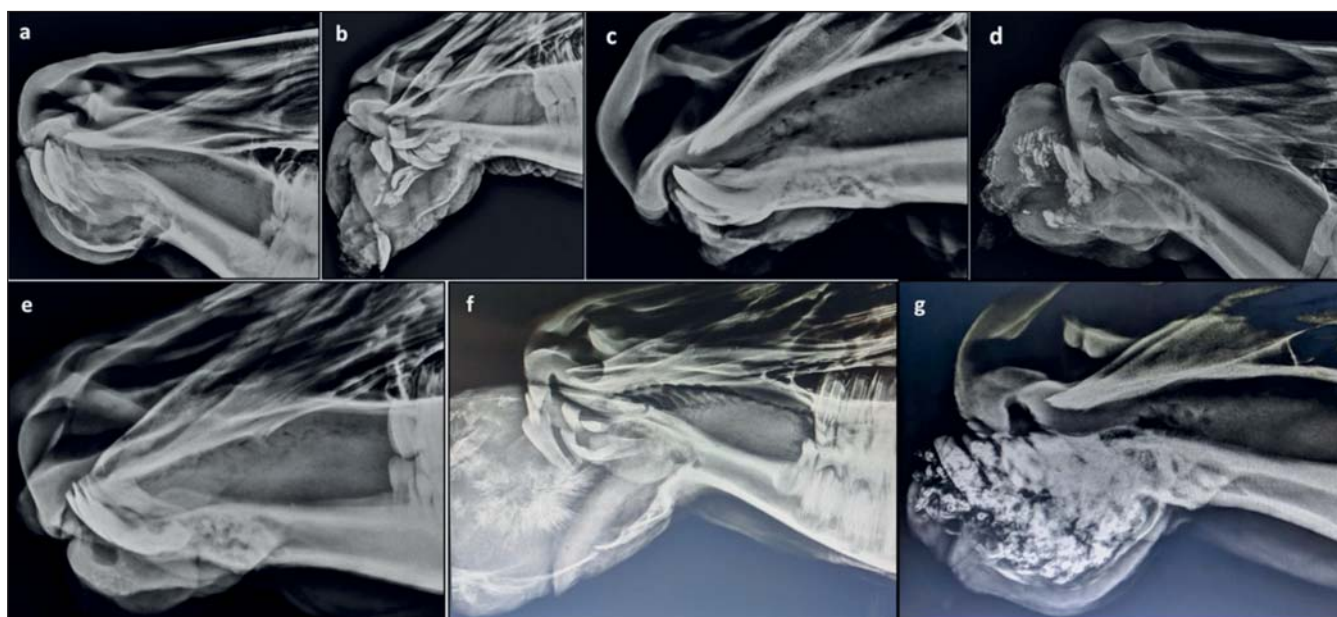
Radiographs of the buffaloes presented with odontoma in lateral view. Radiographs showing cystic opacity with calcified margins (a), dislodged incisors with diffuse calcification and partially encapsulated calcified margins (b), no calcified area of incisor involvement seen (c), mildly mal-aligned incisors with diffuse calcified areas (d), Mild calcification seen cranial to incisors (e), mal-aligned incisors with sunburst calcification seen in the middle of the growth and calcified margins (f), Diffuse calcification seen cranial to incisors with suspected mal-aligned incisors (g).
